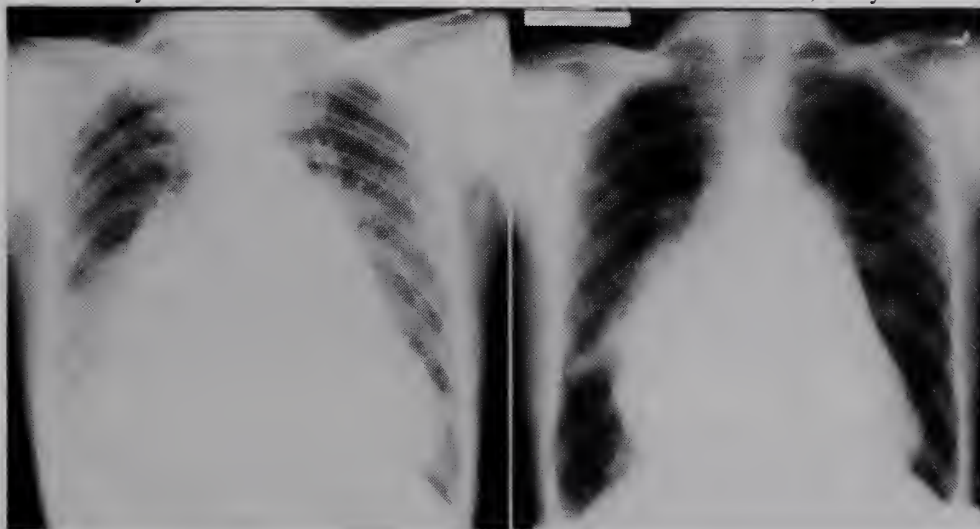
Pre-operative and 7 month post-operative chest roentgenograms on a patient with marked cardiomegaly from chronic rheumatic mitral stenosis and insufficiency.
